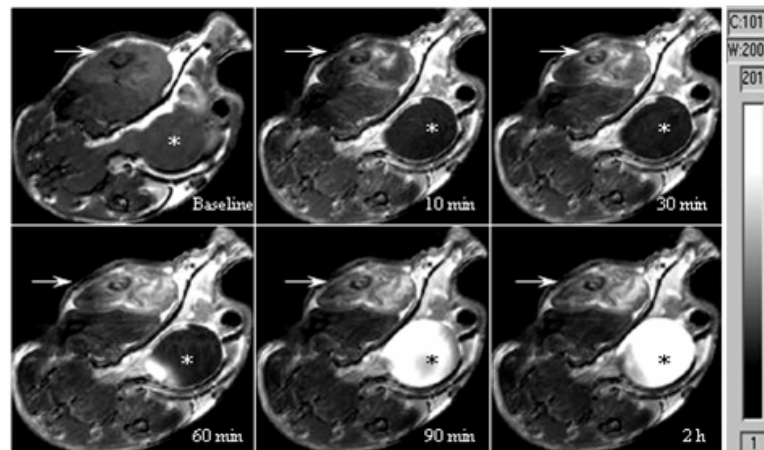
In vivo time course of tumor MRI after i.v. administration of the probe TfNIR-LipNBD-CA, showing gradually increased enhancement of the tumor signal (arrow) and heterogeneous enhancement pattern. Gradual accumulation of CA in the urinary bladder is evident (*). The MRI parameters are TE = 11.416 ms, TR = 800 ms, number of average = 4, field of view = 28 x 30 mm, matrix size = 256 x 192, and slice thickness = 1.0 mm.
